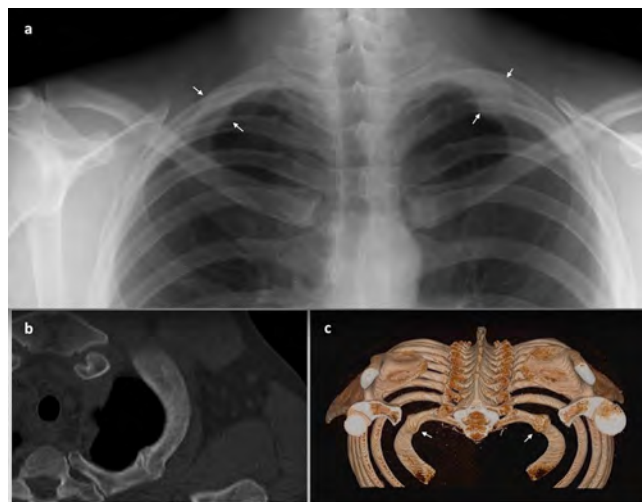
Posteroanterior lung radiography shows old fractures in bilateral first ribs (arrows)(a), Transverse oblique reformatted CT image demonstrates old fracture in left first rib(b). 3D image obtained with volume rendering technique shows the fractures clearly (arrows)(c).
